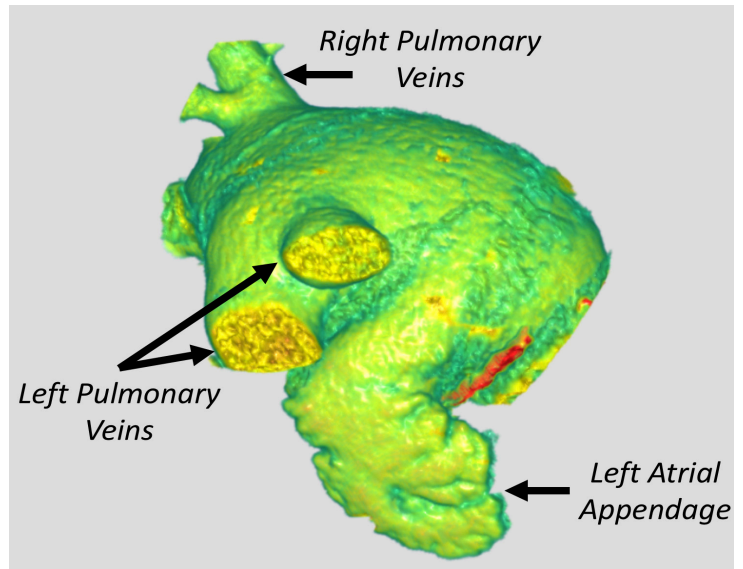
Computed tomography-derived three-dimensional modeling.
